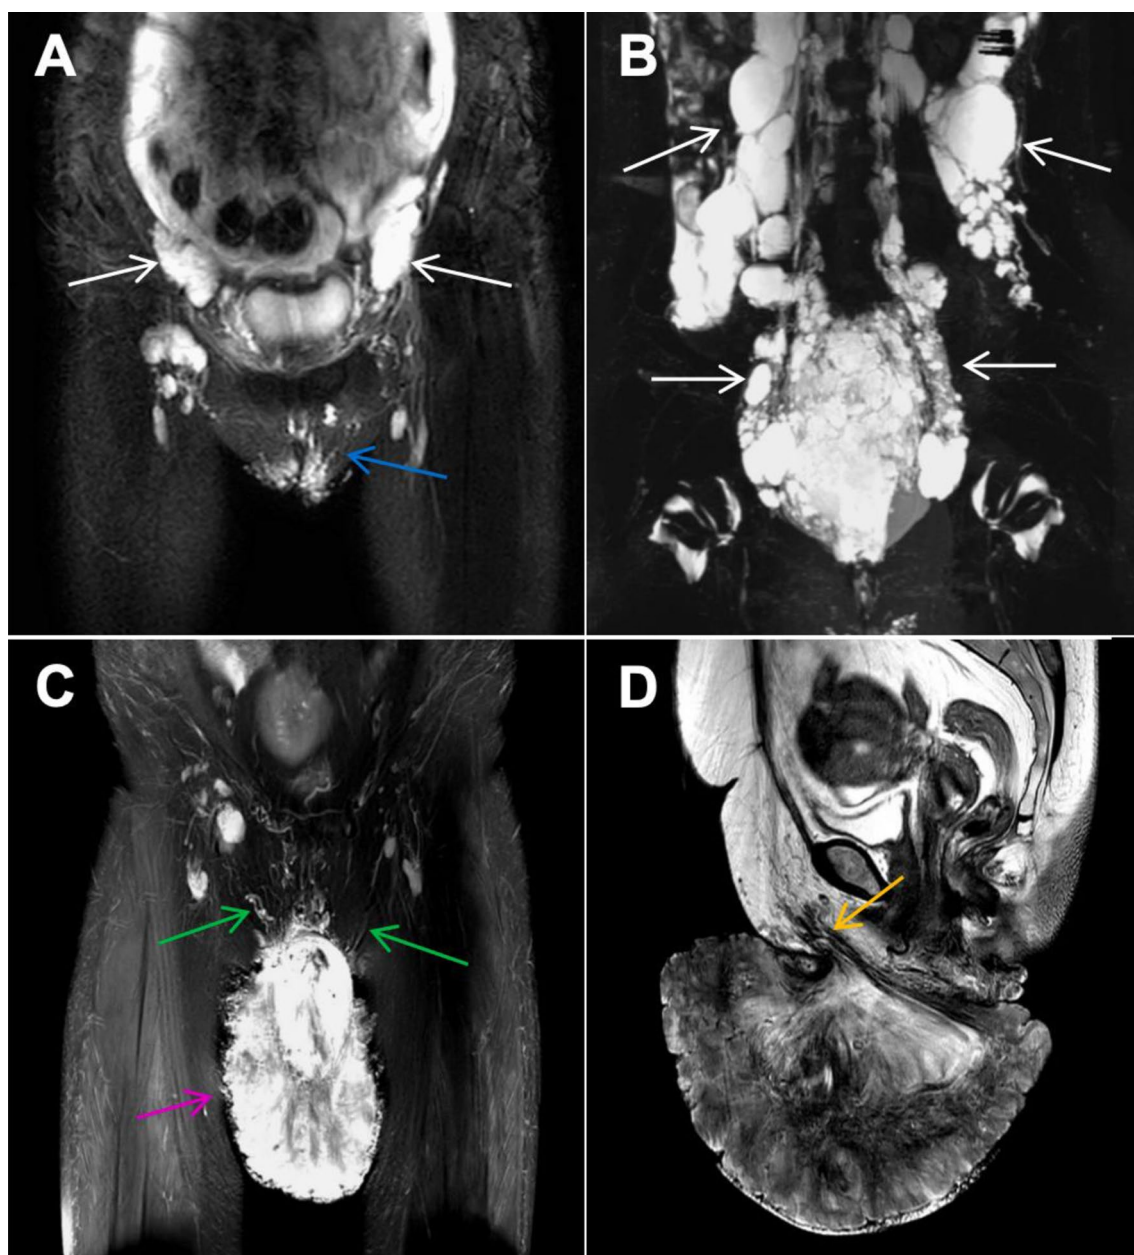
MRI images. A-B, MRI coronal views showed multiple cystic dilated lymphatic vessels in the abdominopelvic region (white arrows), tortuous and dilated lymphatic vessels in labia (blue arrow). C-D, a middle-aged woman had a gradually enlarged soft tissue mass in the vulva accompanied by multiple vesicles and chylous leakage for 15 years after cesarean section. MRI coronal view showed a huge soft tissue mass (pink arrow) in the vulva with multiple earthworm-like nourishing lymphatic vessels (green arrows). MRI sagittal view showed the mass originated from the vulva (orange arrow)
